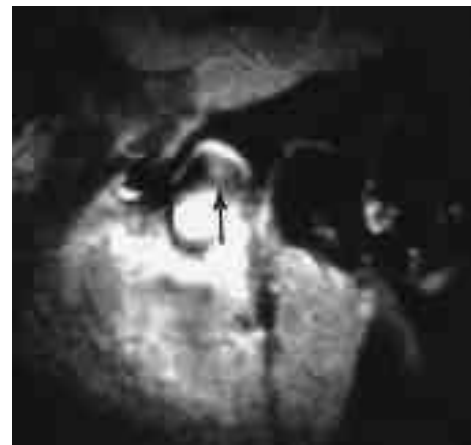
Sagittal T2-weighted image of 53-year-old female patient with right condylar neck fracture demonstrates high signal intensity of retrodiskal tissue (arrow).
